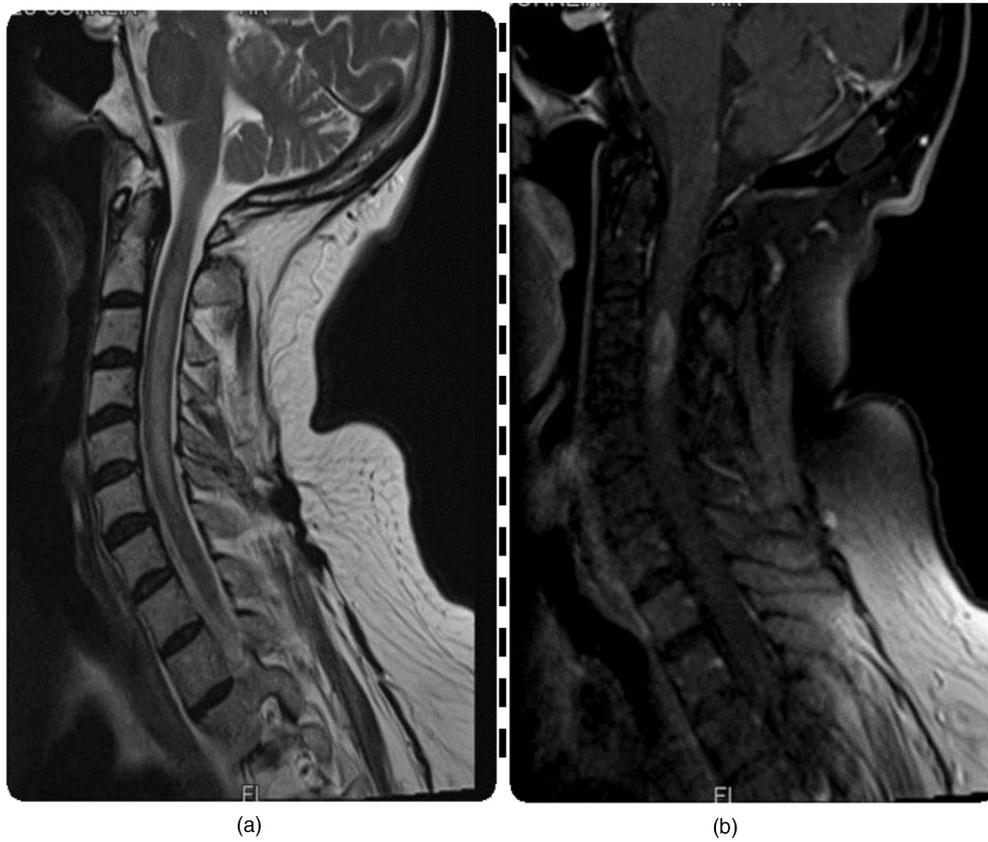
MRI-FLAIR showing C1 to C7 medullary lesion involving almost entirely medullary cross-sectional on an axial plane (– 1a). The lesion is asymmetrical being more extensive on the right. Gadolinium enhancement (– 1b) on the right medulla (C3 and C4).
